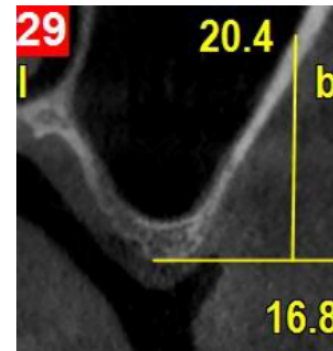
Measuring the artery to crest distance in CBCT cross-sectional image.
